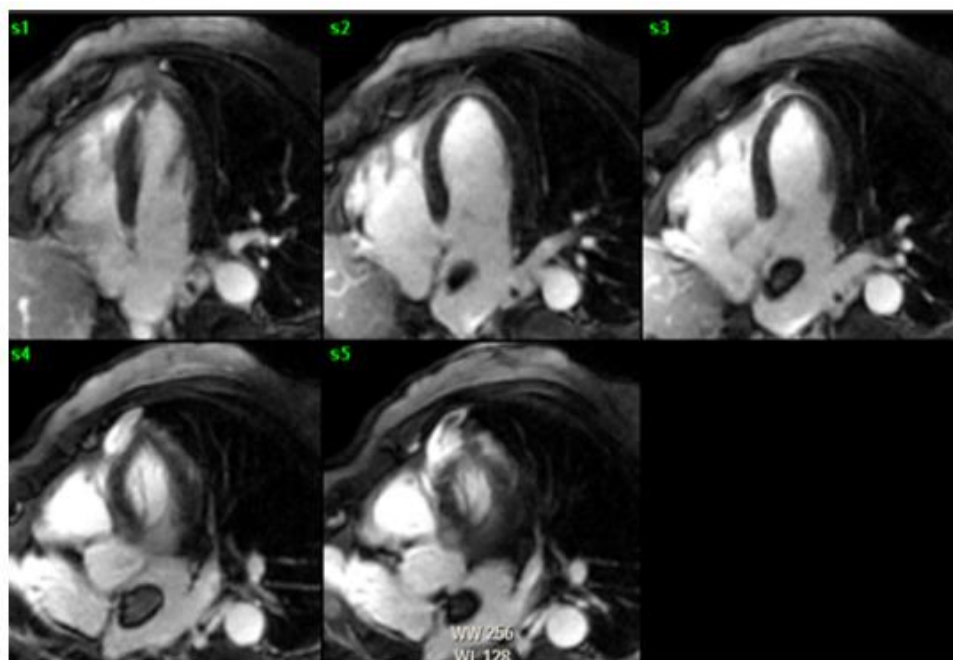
Cardiac MRI showing late gadolinium enhancement of all four chambers, revealing a mass attached to the interatrial septum without fibrosis, which suggests the presence of an atrial myxoma.
